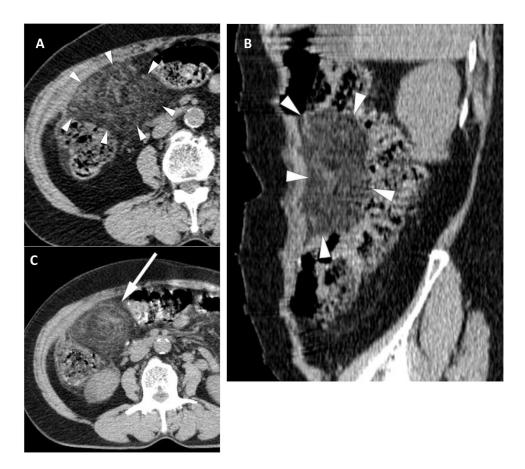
The CT images show a fatty mass in the right iliac fossa with ill-defined borders and surrounding fat-stranding (A). The mass is anterior to the bowel loops and is in the area of the omentum (B). On 10 mm MIP CT, the greater omentum has a hazy appearance with concentric hyperdensity and exhibits streaks of the whirling pattern (omental whirl sign) (C).
